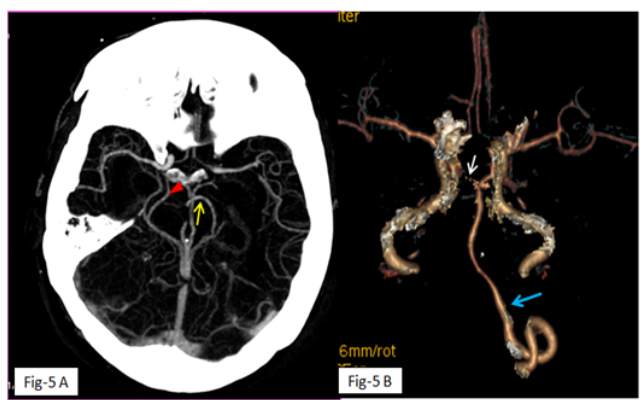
A, Axial cerebral CTA image and Fig-5 B, 3D cerebral CTA image showing the fetal origin of the right posterior cerebral artery (PCA): as the ipsilateral P1-segment (the first segment of PCA) is hypoplastic (white arrow) and the caliber of the posterior communicating artery (red arrow-head) is greater than that of the ipsilateral P1 segment. Note the normal left PCA (yellow arrow). The right vertebral artery is absent. Note the normal left vertebral artery (blue arrow).
